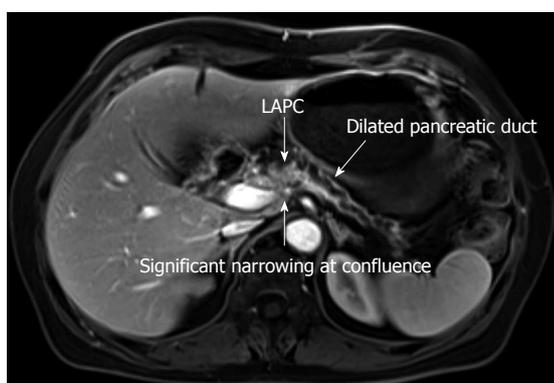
Magnetic resonance imaging of locally advanced pancreas cancer with vascular invasion and dilated pancreatic duct. LAPC: Locally advanced pancreatic cancer.
